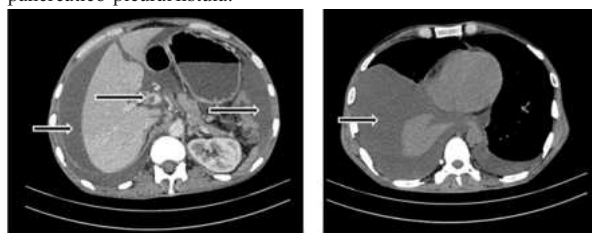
Axial image of contrast enhanced CT examination shows peri hepatic free fluid [ascites], portal vein thrombosis & peri splenic free fluid [ascites], pleural effusion (arrow) as extra pancreatic complications of acute pancreatitis.
